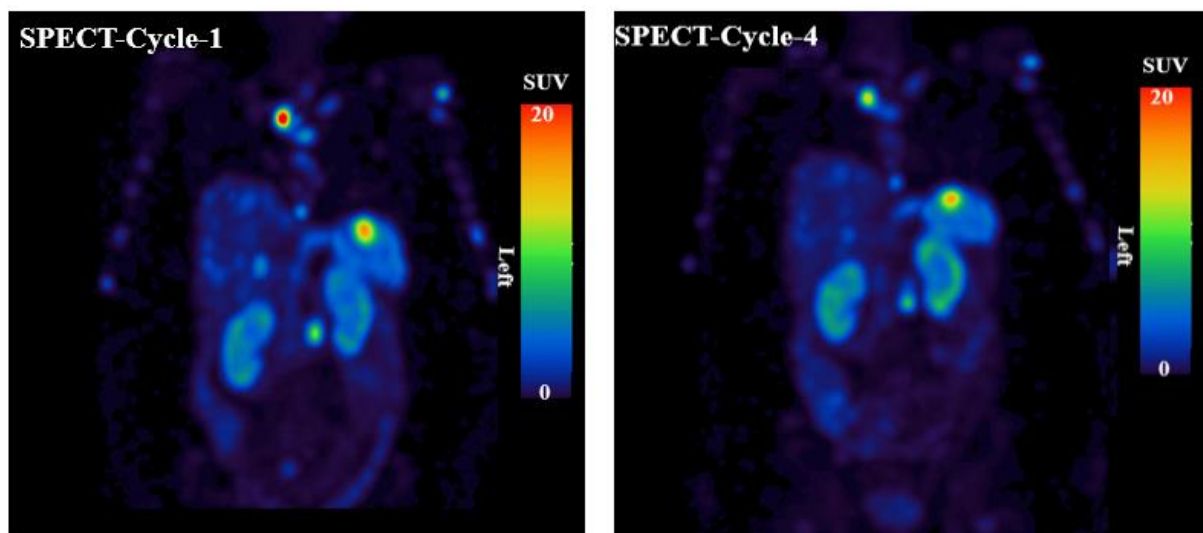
Example of SPECT/CT MIP image following PRRT cycles 1 and 4. Patient DOTA-15 showed increased radiation restriction by 6 days for sleeping apart from a partner and contact with children <2 years old, and by 4 days regarding contact with children >2–11 years old.
